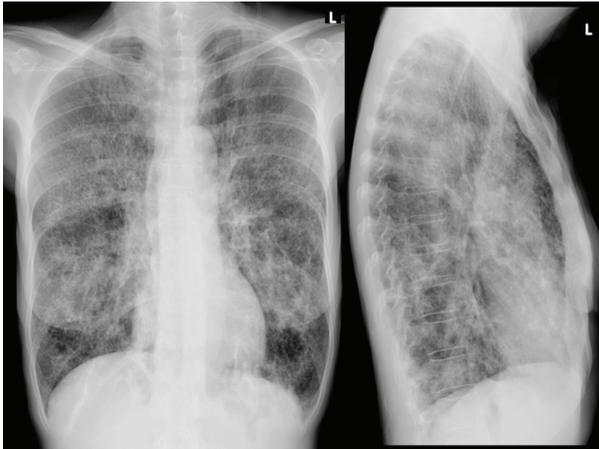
Chest x-ray taken at presentation.
